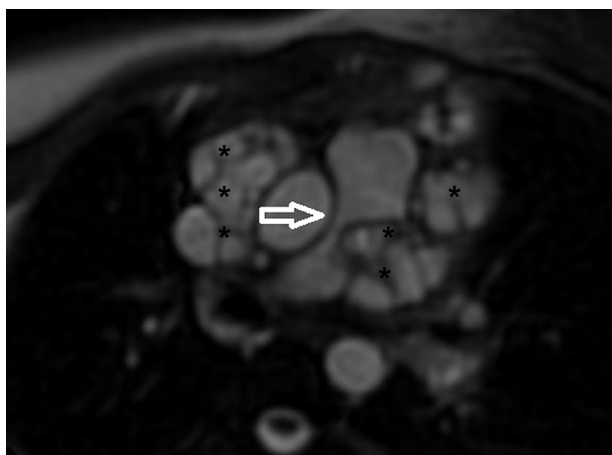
Cardiac magnetic resonance imaging showing external compression of pulmonary artery. Black asterisks indicate hydatid cysts.
